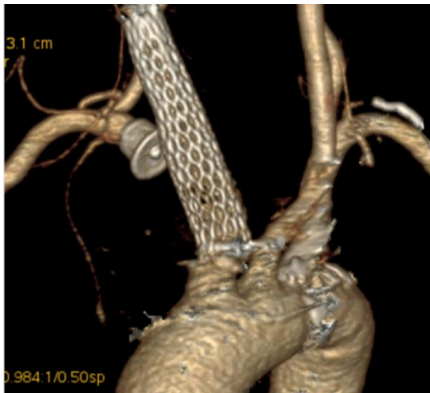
CT Angiogram done in the follow up period shows complete exclusion of the aneurysm.
